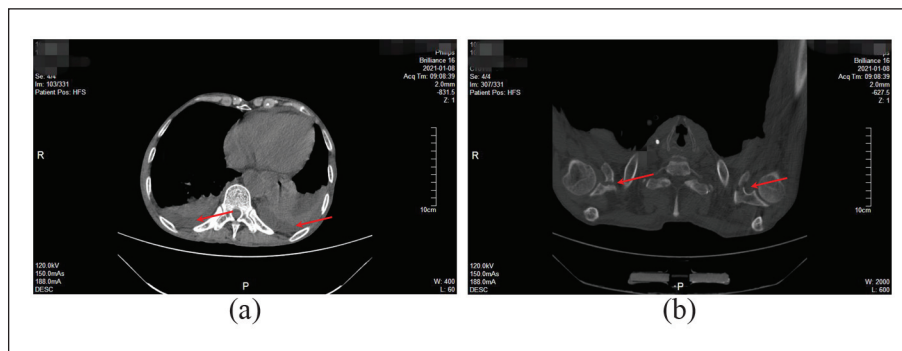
CT scan on 8 January 2021, indicating bilateral pleural effusion (a, red arrows) and bilateral coracoid process fracture, with no obvious bone destruction at the fracture end (b, red arrows).
